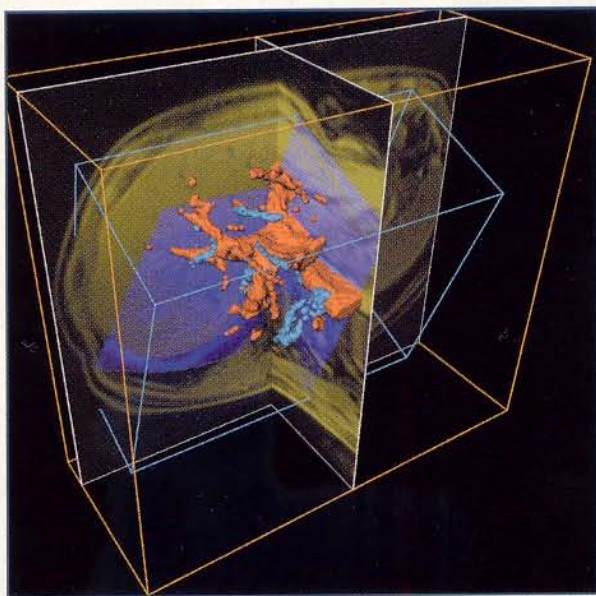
A 3-D liver image shows the result of vessel registration and data fusion between two image modalities: MRI (yellow) and ultrasound (blue). Courtesy of Brian Porter, University of Rochester.
